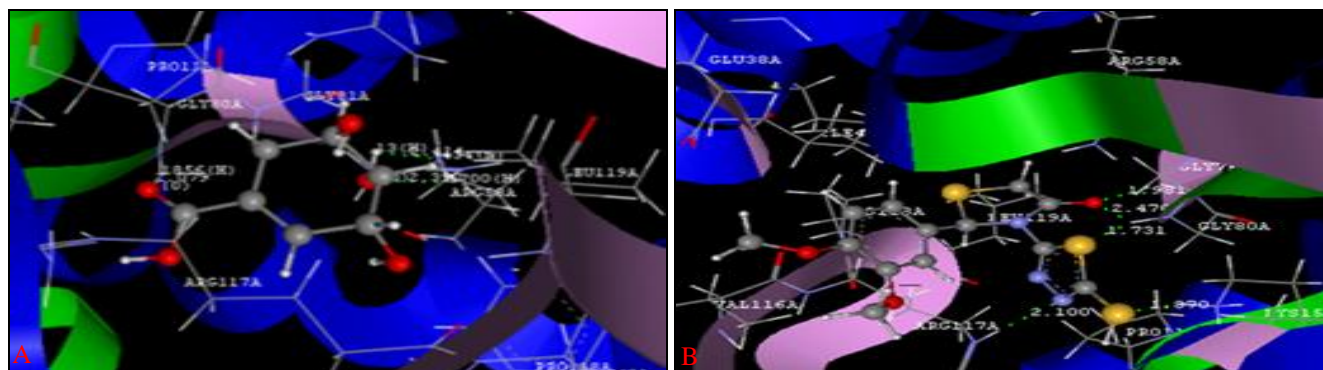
(A) AND 2(B): HYDROGEN BONDING INTERACTIONS OF SHIKIMATE WITH GLY80, ARG58 (2A) AND OF (4J) WITH LYS15, GLY80, GLY81, ARG117 IN THE ACTIVE SITE OF SK (PDB CODE: 2IYQ) RESPECTIVELY. (SHOWN IN GREEN DOTTED LINES)
